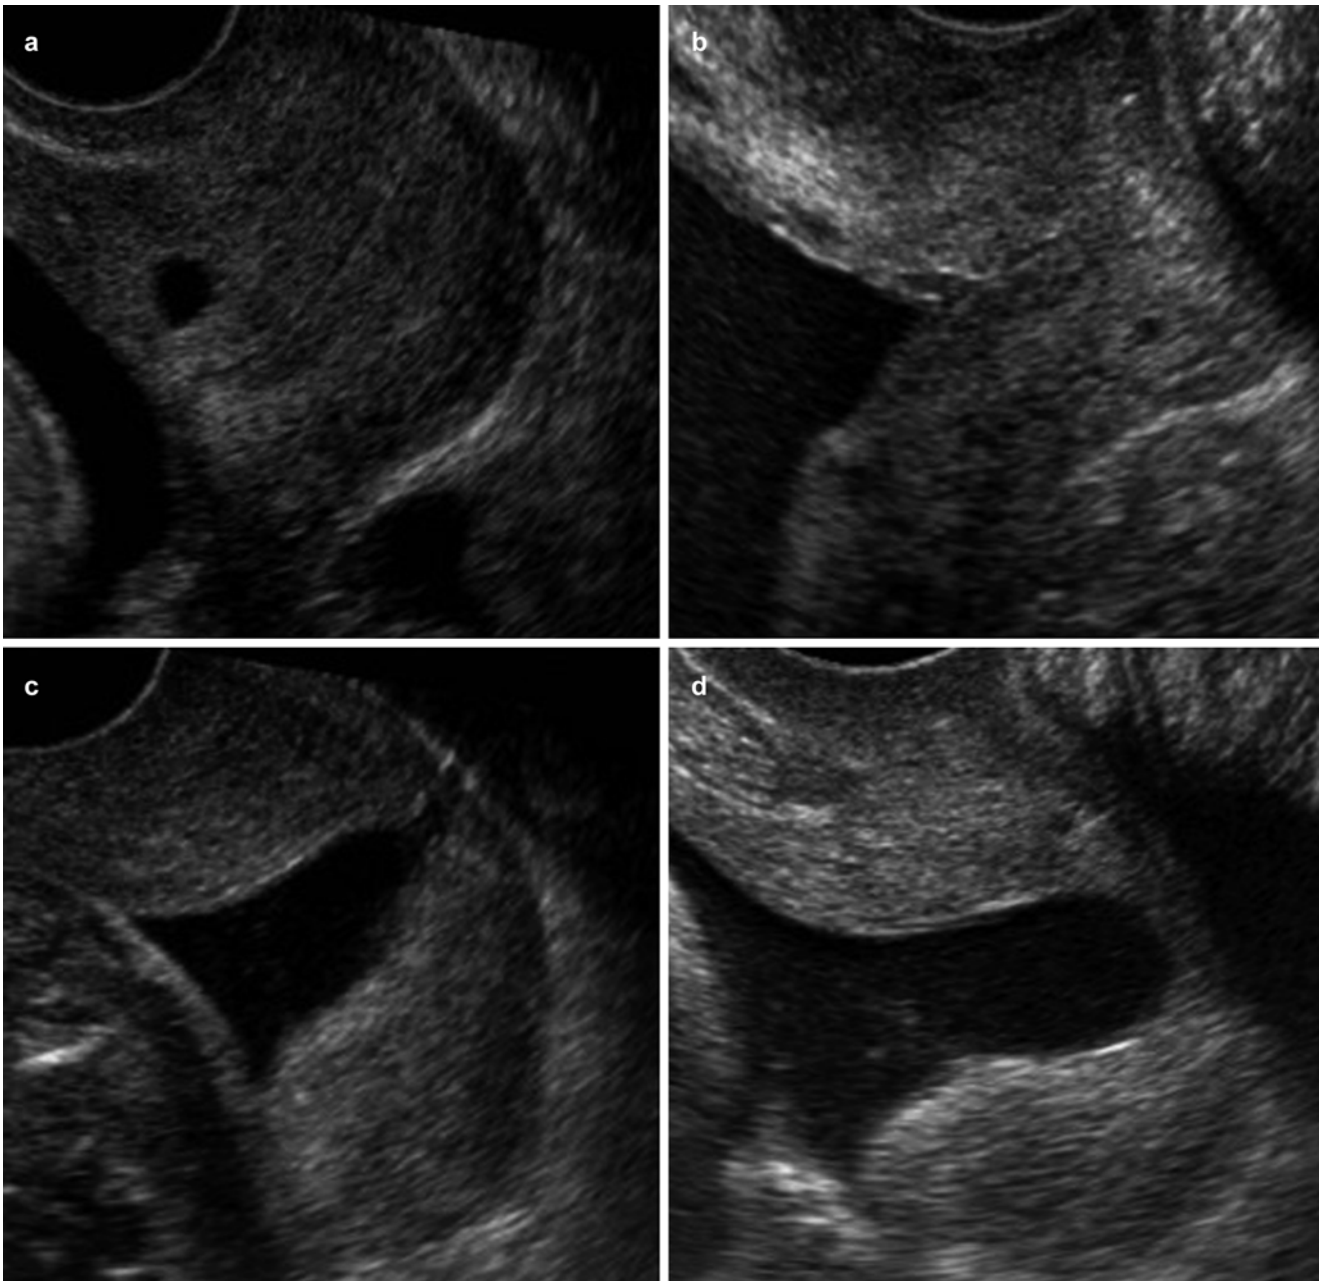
Transvaginal sonography of the cervix shows the respective shapes of the cervical funnels (TYVU shapes)
